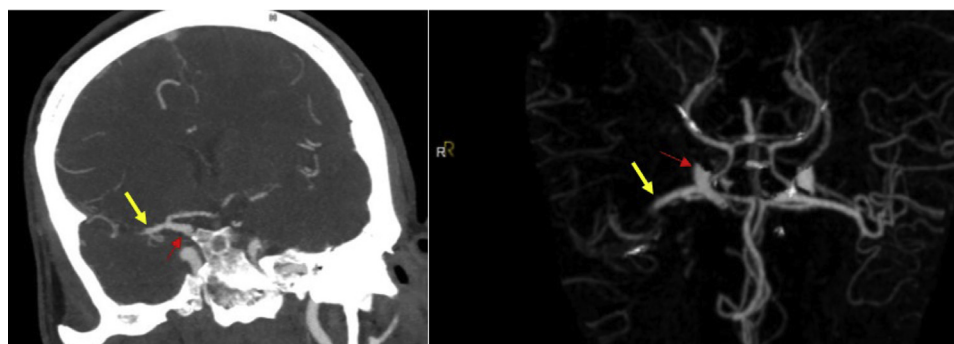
Computed tomography angiogram with perfusion demonstrating acute nonocclusive thrombus in the distal M1 segment of the right middle cerebral artery (MCA; yellow arrow). The red arrow identifies the right internal carotid artery (ICA).
